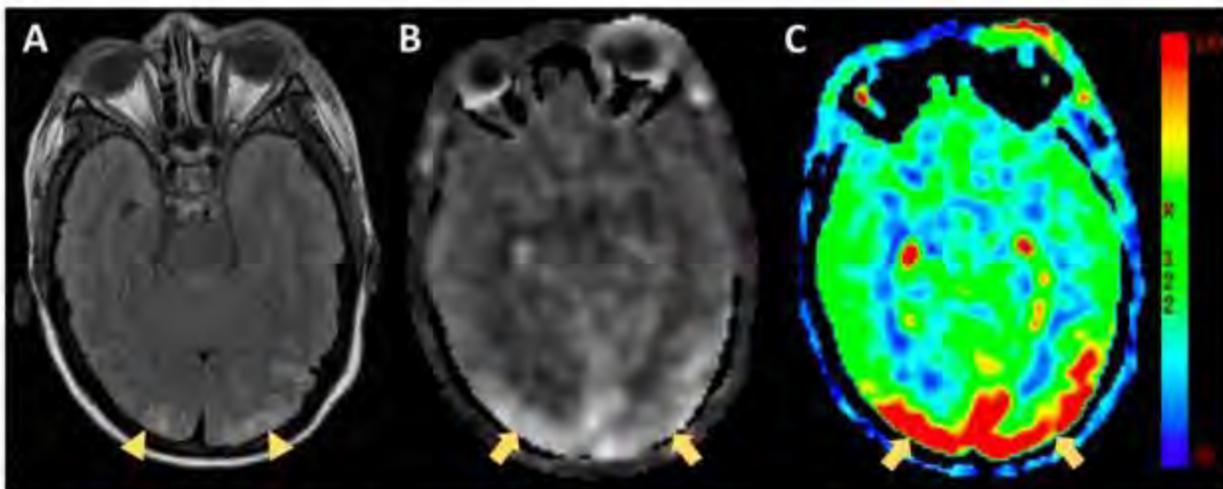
Axial T2 FLAIR (A), ASL grayscale (B) and ASL color (C) perfusion maps in a 23-year-old female with Tacrolimus induced PRES. Hyperperfusion (arrows) is noted corresponding to the regions of FLAIR hyperintensity (arrowheads). Color bar ranges from 20 to 130 ml/100g-min.
